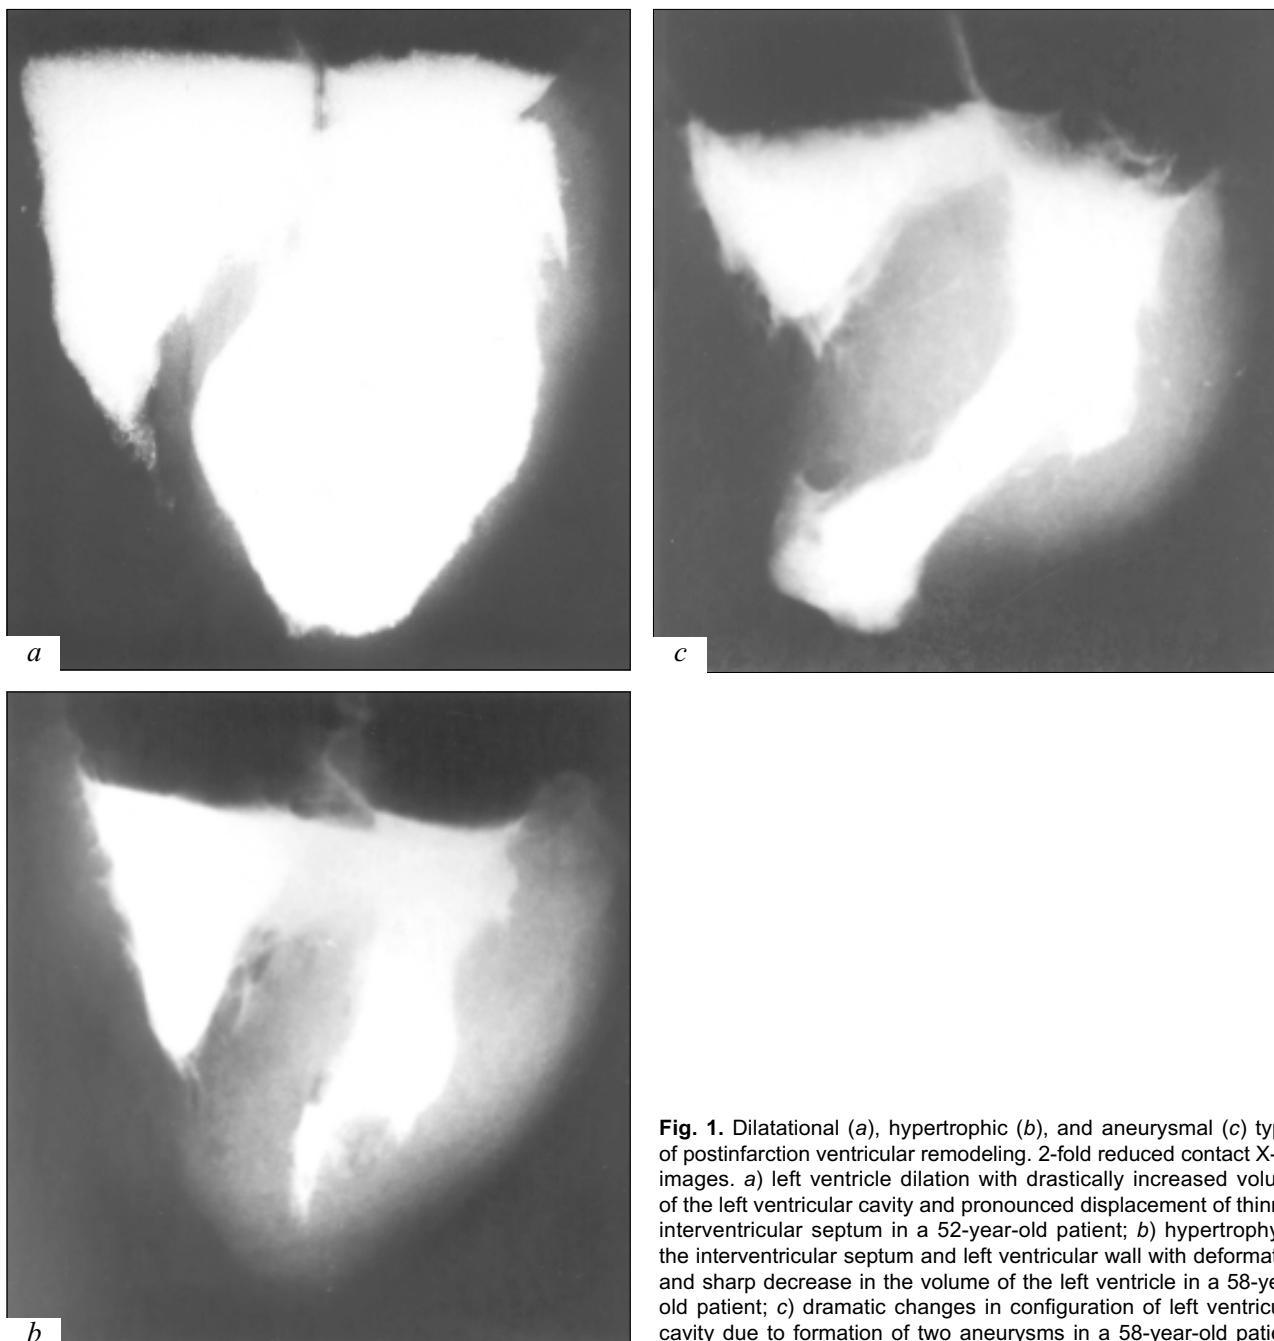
Dilatational (a), hypertrophic (b), and aneurysmal (c) types of postinfarction ventricular remodeling. 2-fold reduced contact X-ray images. a) left ventricle dilation with drastically increased volume of the left ventricular cavity and pronounced displacement of thinned interventricular septum in a 52-year-old patient; b) hypertrophy of the interventricular septum and left ventricular wall with deformation and sharp decrease in the volume of the left ventricle in a 58-year-old patient; c) dramatic changes in configuration of left ventricular cavity due to formation of two aneurysms in a 58-year-old patient.
